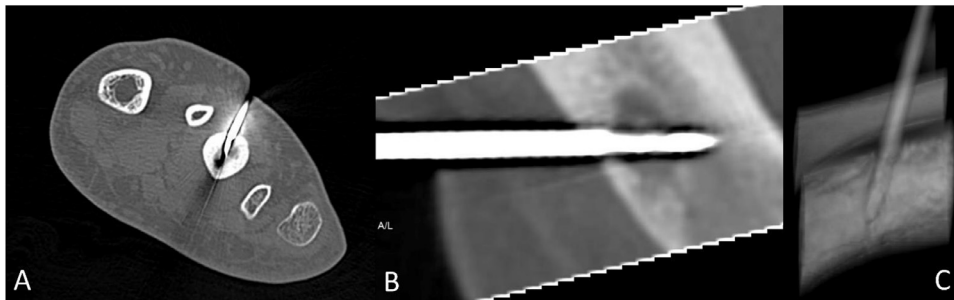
Intraoperative CT scan showing correct positioning of needle during procedure of thermal ablation (coronal view [A], sagittal view [B] and 3D shaded surface display (SSD) [C]).
